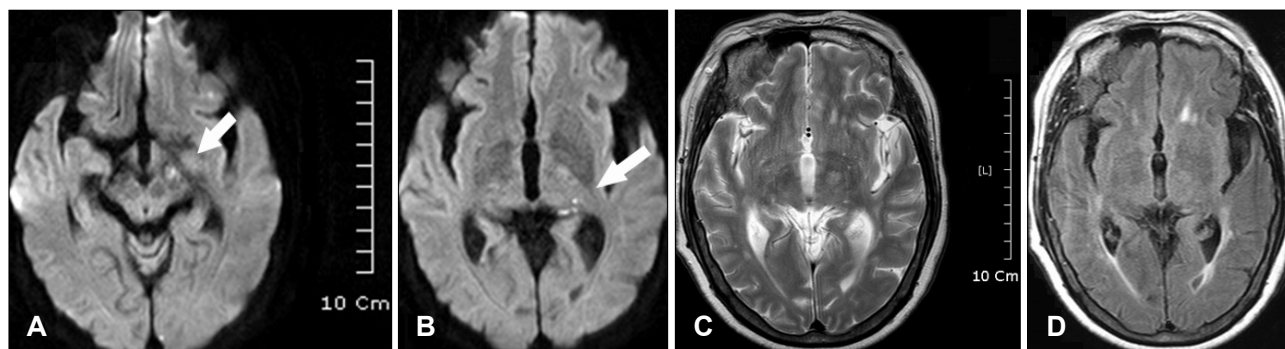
Diffusion weighted MR images shows acute small infarctions on left subthalamic area and upper midbrain (A and B, arrows). These tiny lesions are scarcely visible on T2 weighted (C) or FLAIR image (D). FLAIR: fluid-attenuated inversion-recovery.
